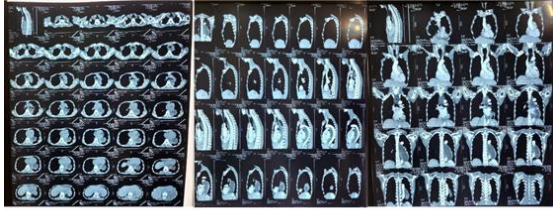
CT scan of the thorax shows narrowing of the distal esophagus (approximately 2.2 cm) accompanied by widening of the proximal segment with a widest diameter of 5.7 cm, suggesting primary achalasia.
